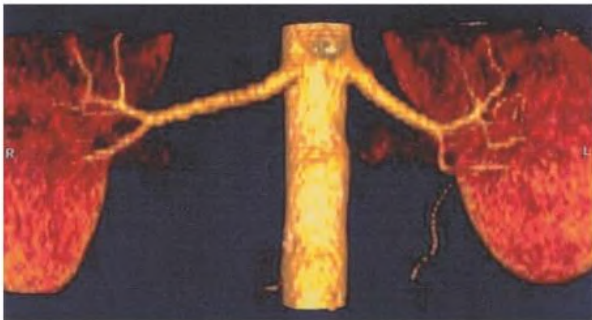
Normal Renal Arteries. Three-dimensional reformatted computed tomography angiogram.
